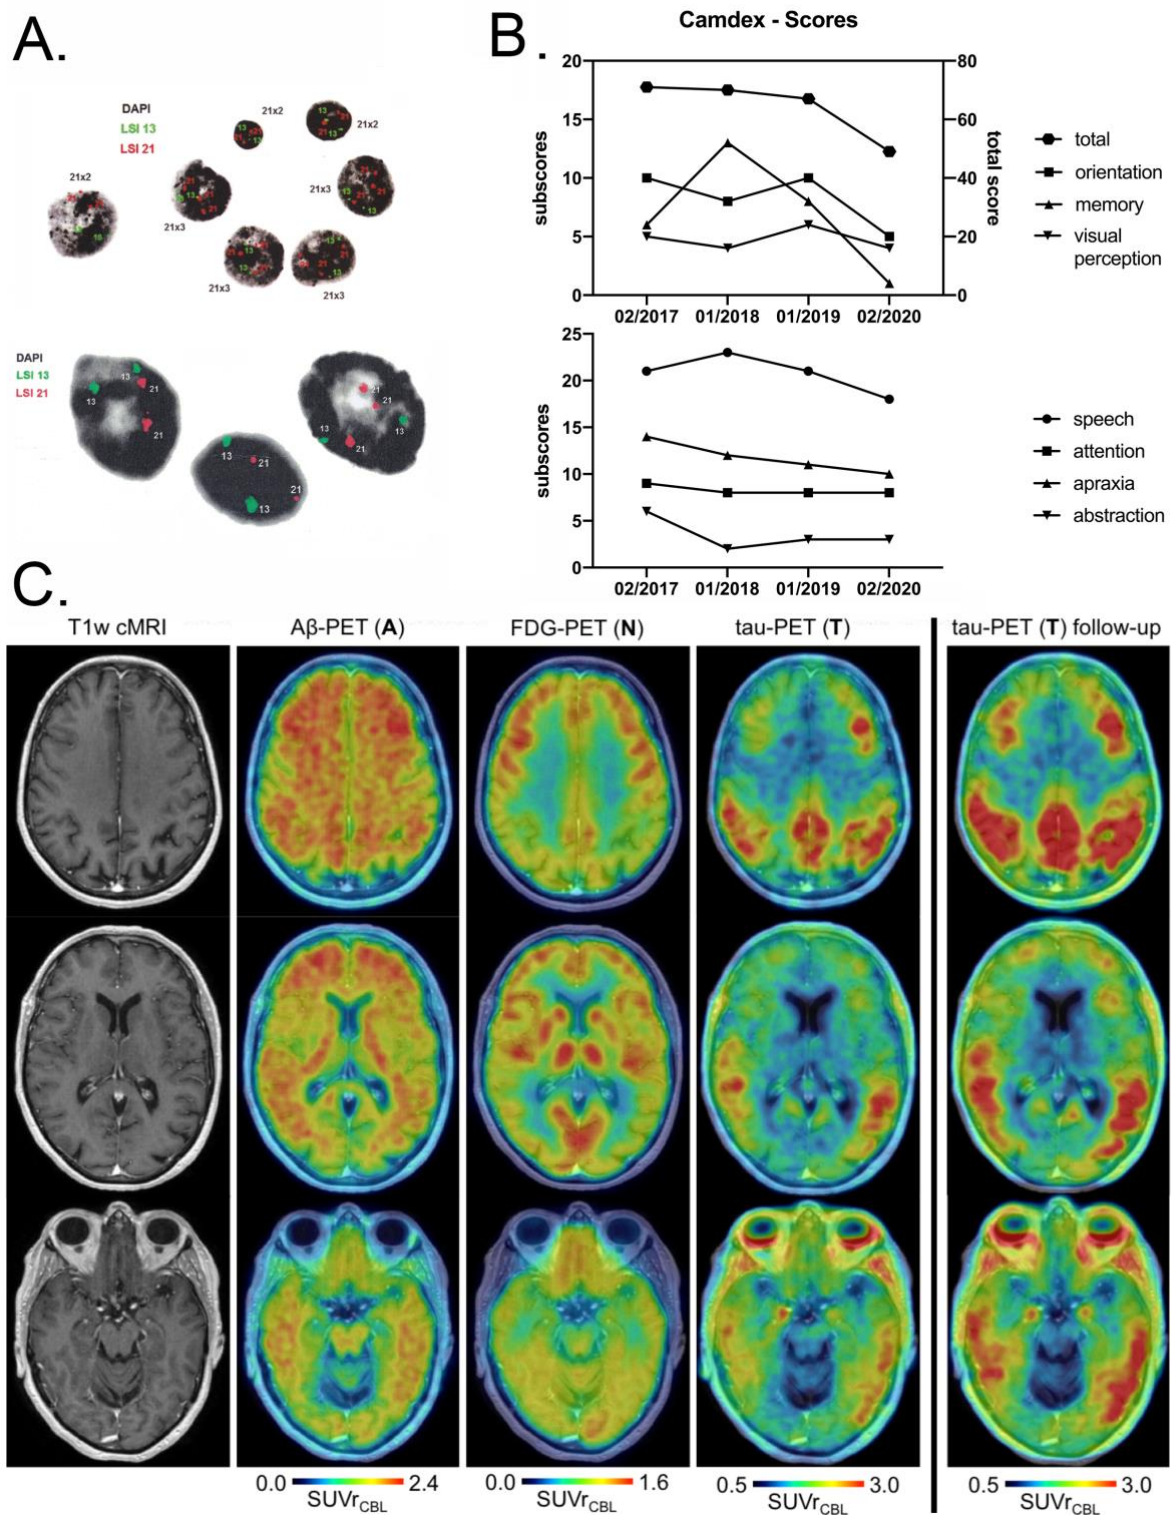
MRI and PET imaging
